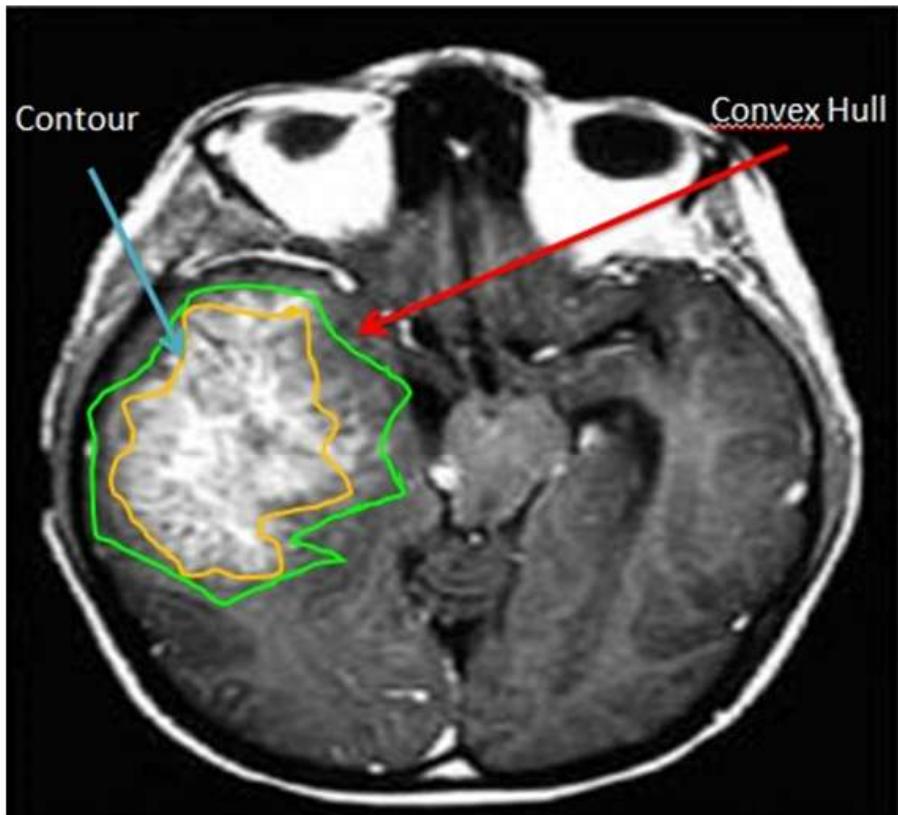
Results of brain tumor segmentation on the first exam MRI slices
